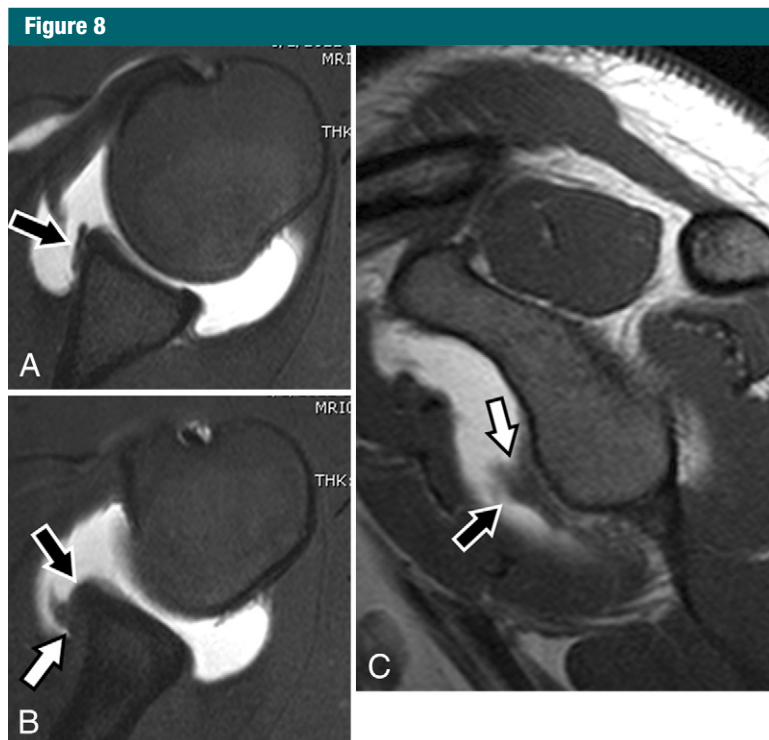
Chronic ALPSA in a young baseball player with clinical findings of anteroinferior instability and no history of prior dislocation. *A, B*, Axial and, *C*, sagittal fat-suppressed T1-weighted MR arthrograms demonstrate a medially displaced anteroinferior labral tear (black arrows) and stripped off scapular periosteum with scar tissue annealing the fragment and periosteum to the inferomedial scapular neck (white arrows). (Image courtesy of Jason Mayo, MD.)
